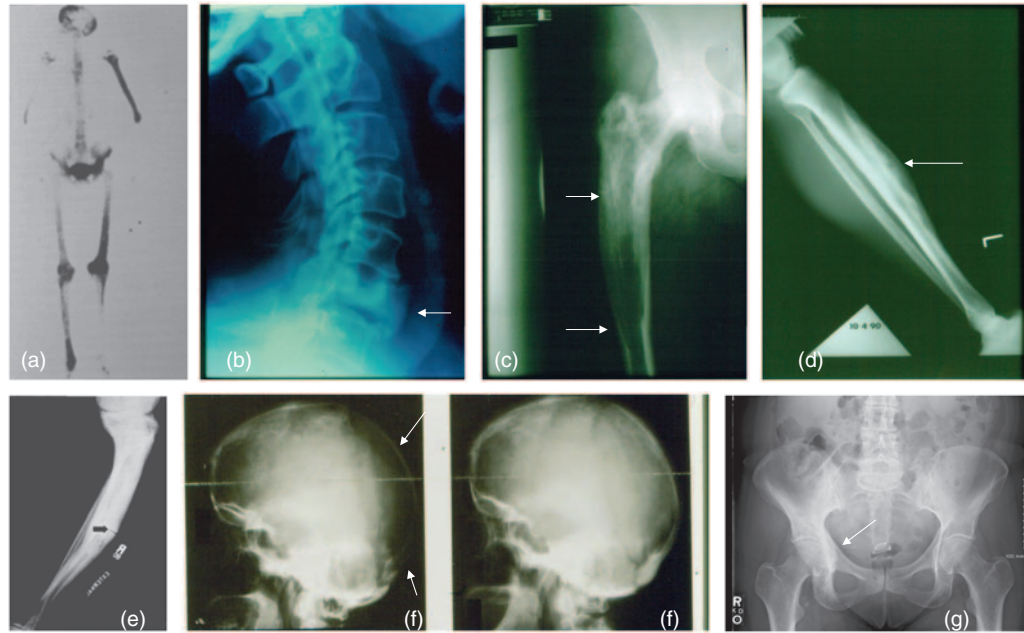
Radiographic appearance of Paget's disease of bone (PDB). (a) Bone scan in polyostotic PDB (with permission, courtesy of The Paget Foundation for Paget's Disease of Bone and Related Disorders). (b) Enlarged and osteosclerotic vertebral body. (c) Pagetic femur with osteosclerotic area proximal to a lytic front. (d) Lytic area in enlarged pagetic tibia. (e) Fissure fracture in a pagetic tibia (with permission, courtesy of The Paget Foundation for Paget's Disease of Bone and Related Disorders). (f) Lytic area in pagetic skull (osteoporosis circumscripta) with remineralization after aminobisphosphonate therapy. (g) PDB involving the right hemipelvis.
